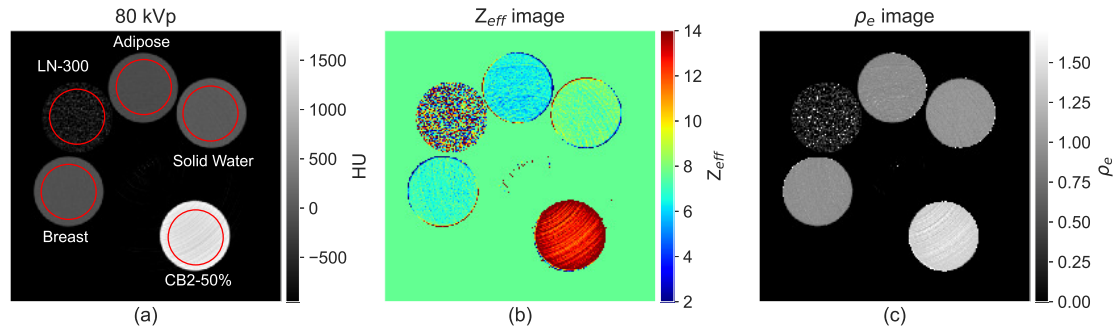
DECT images of the second evaluation subset of tissue equivalent materials and water. (a) 80 kVp CT image with labeled materials and ROIs depicted in red. (b) Effective atomic number image. (c) Relative electron density image.
